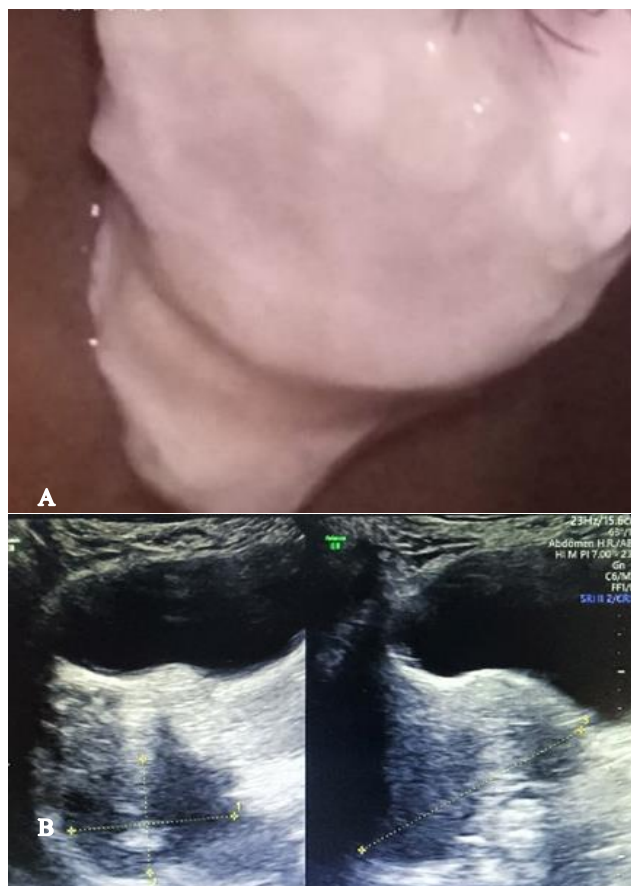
(A and B): Patient presented with expulsion of placental products after two months. Gross appearance of the same is depicted in (A) and pelvic ultrasonography after expulsion revealed minimal retained products.
